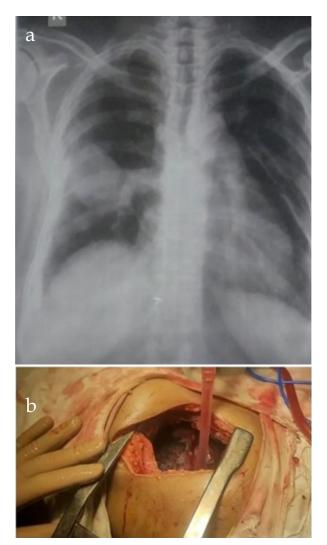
a) Preoperative X-ray chest PA view, b) operative procedure
